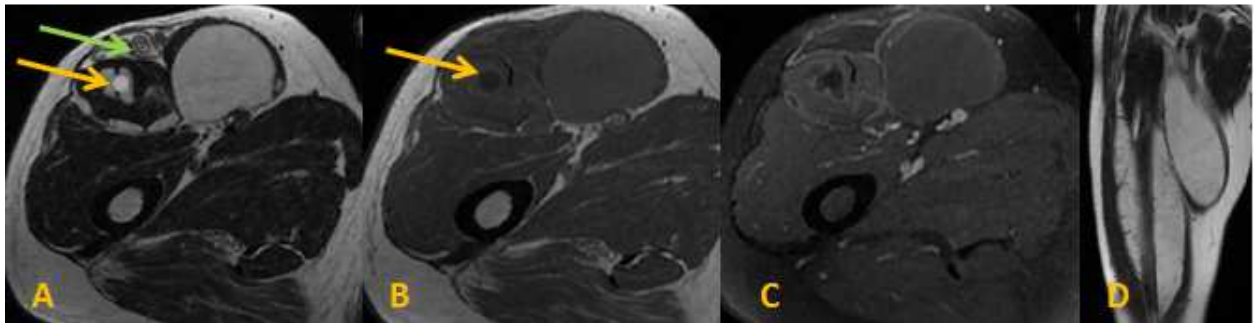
MRI imaging on T2 weighted ponderation (A, D), T1 weighted ponderation (B) and on injected T1 FAT SAT weighted ponderation (C), showing the intramuscular cystic lesion, no-enhanced after gadolinium administration, with daughter cyst (yellow arrow) and hydatid membrane (green arrow).
